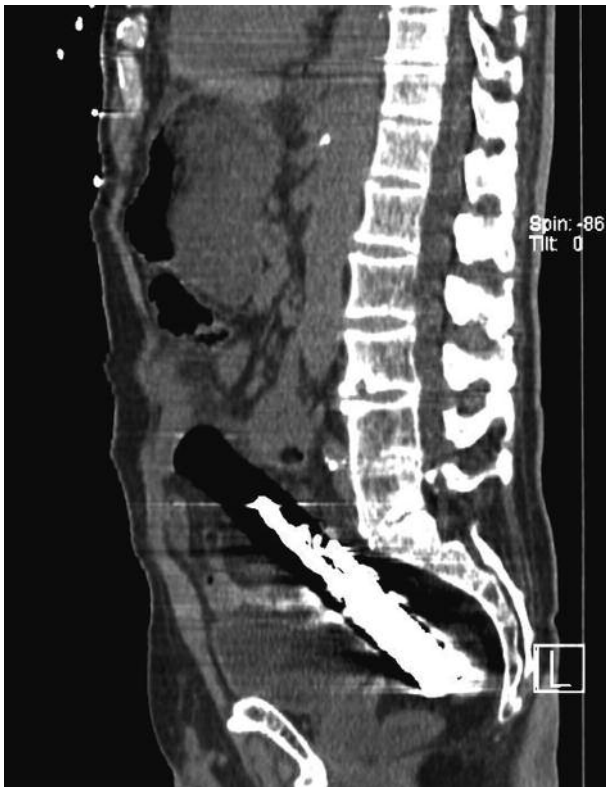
CT scan : no pneumoperitoneum visible
